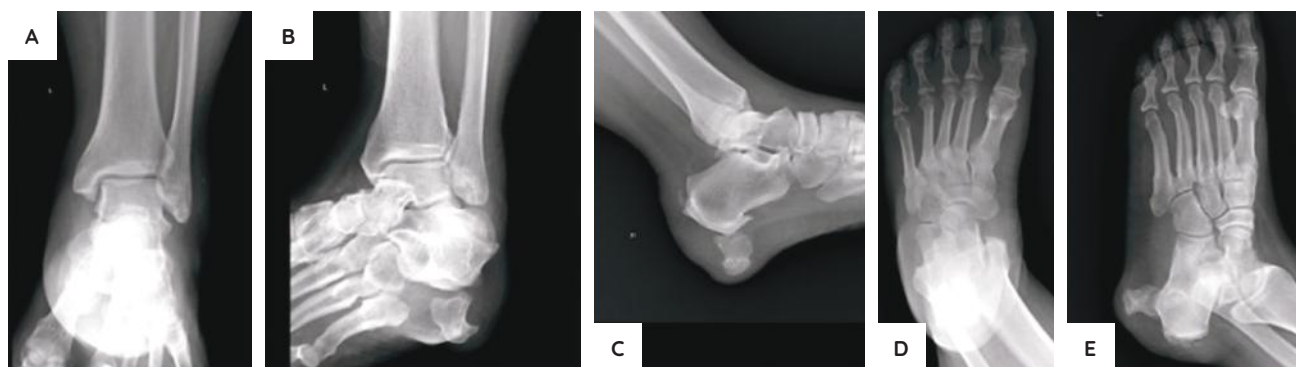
Radiographs of the patient's left ankle and foot showing the anterior-posterior view of the left ankle (A), mortise view of the left ankle (B), lateral view of the ankle clearly showing an extraosseous lesion inferior to the calcaneal tuberosity (C), anterior-posterior view of the left foot (D), and oblique view of the left foot (E).
